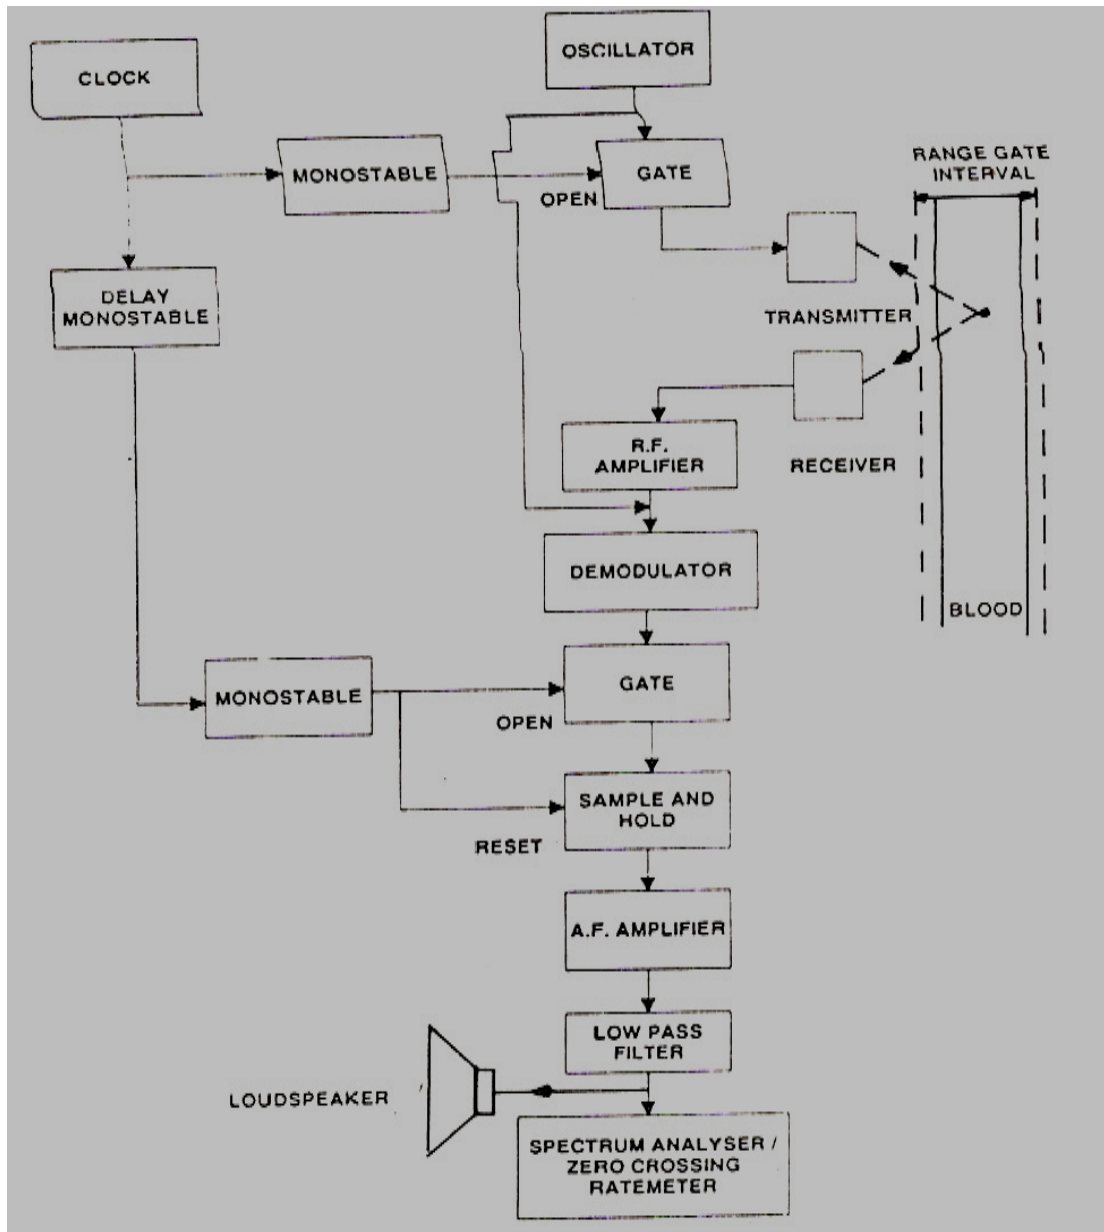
FIG - PULSED DOPPLER BLOOD FLOWMETER
